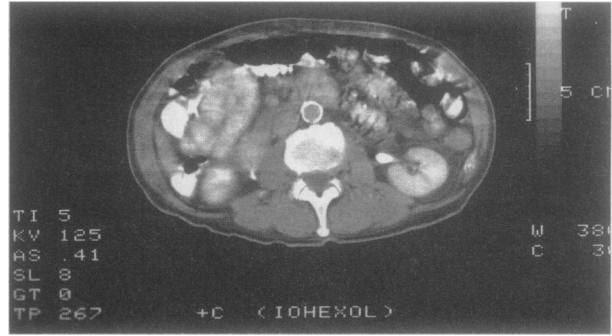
Computed tomography of the abdomen confirms pneumoperitoneum and demonstrates pneumatosis cystoides intestinalis and air in the portal vein (Patient 4).
